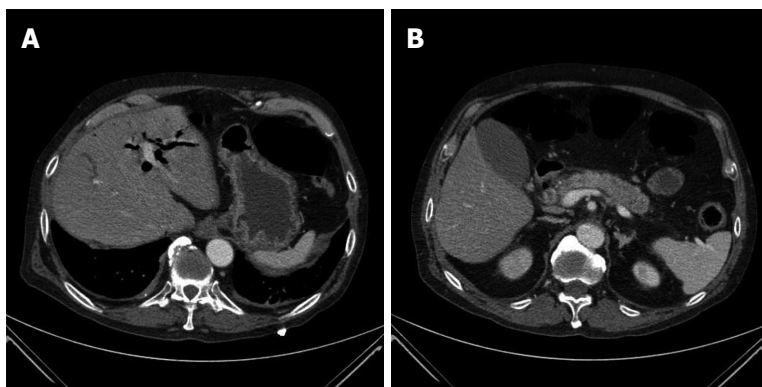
Computed tomography scans of the abdomen performed on admission. A: Dilatation of intrahepatic bile ducts; B: Dilatation of extrahepatic bile ducts with wall thickening and contrast enhancement in the arterial phase of distal common bile duct and increased volume of the pancreas with loss of physiological lobular appearance.
